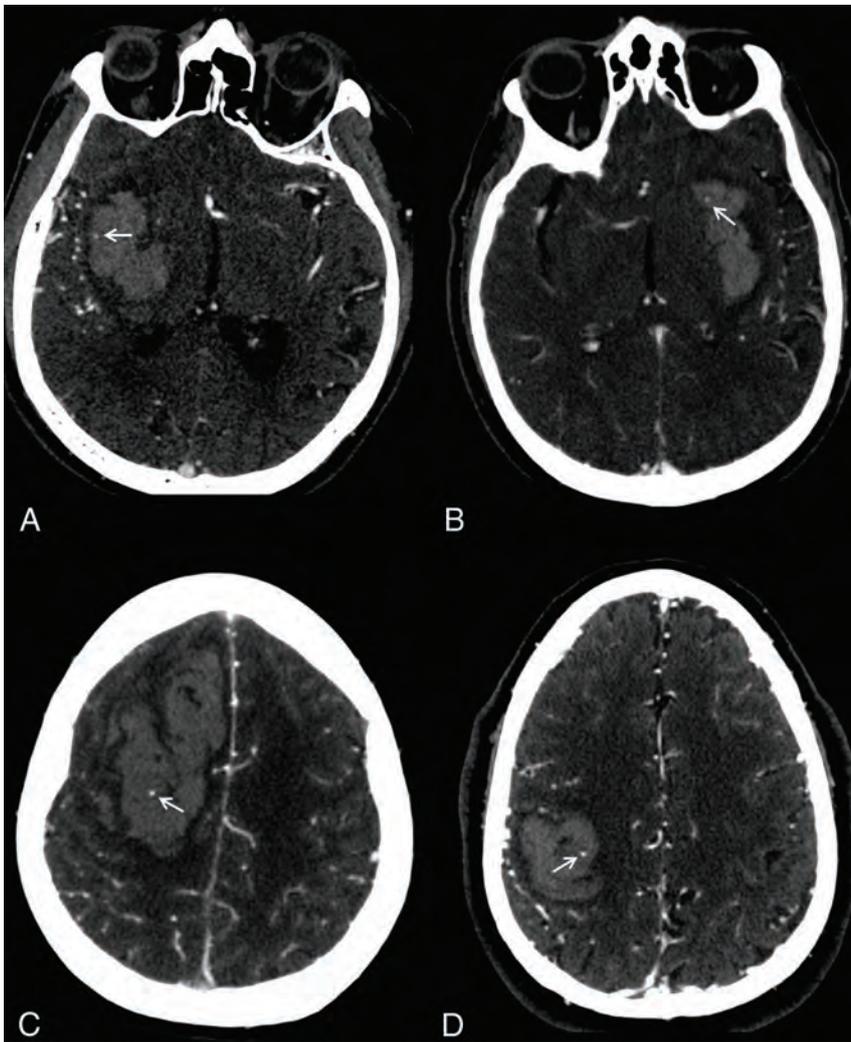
Appearance of the spot sign (arrows) on CTA images obtained at low tube current (A, 170 mA; B, 235 mA) versus high tube current (C, 350 mA; D, 350 mA). All images were acquired on the same scanner at 120 kVp.
